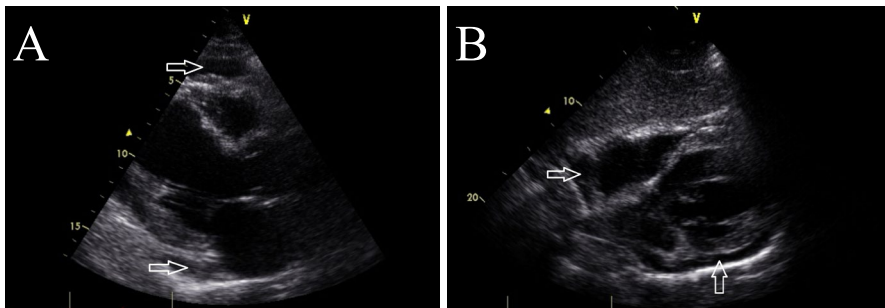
Echocardiography (A) parasternal (B) long axis view
